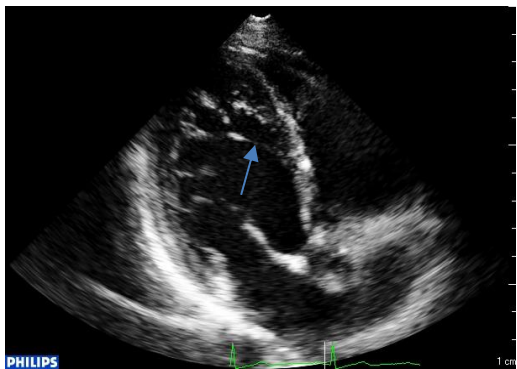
Ventricular membrane in apical three-chamber view
